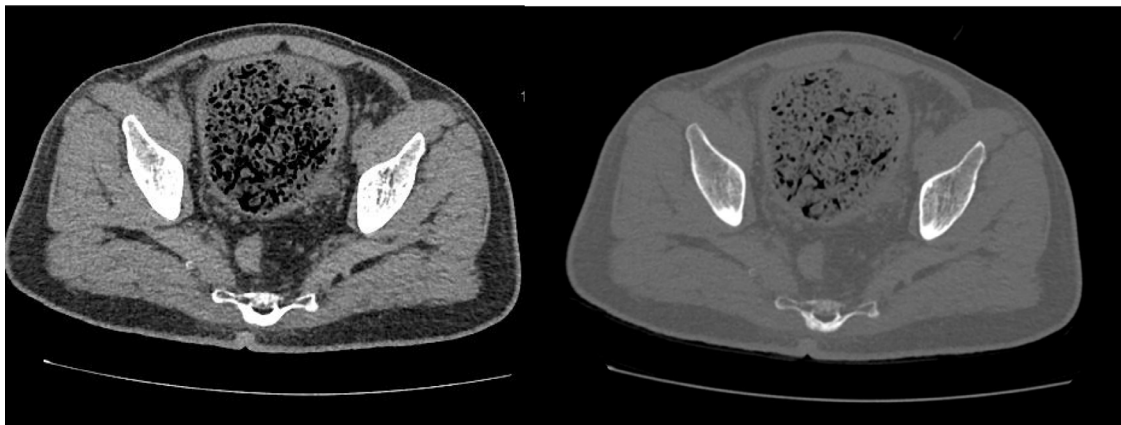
Same axial images of plain computed tomography were shown in different windowing settings. The left image showed narrow windowing (WW400, WL40), while the right image showed more wider windowing (WW1000, WL100). The right image showed a better delineate spherical shape of fungal bezoars.
